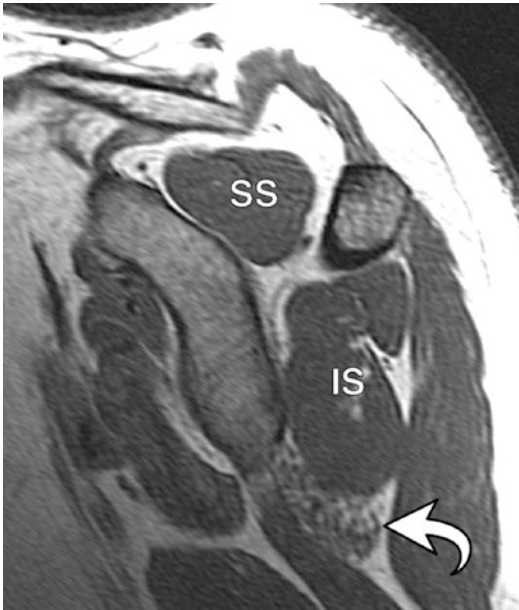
36-Year-old male T1-weighted sagittal oblique image showing isolated atrophy of the teres minor muscle (curved arrow). SS, supraspinatus muscle, IS infraspinatus muscle
